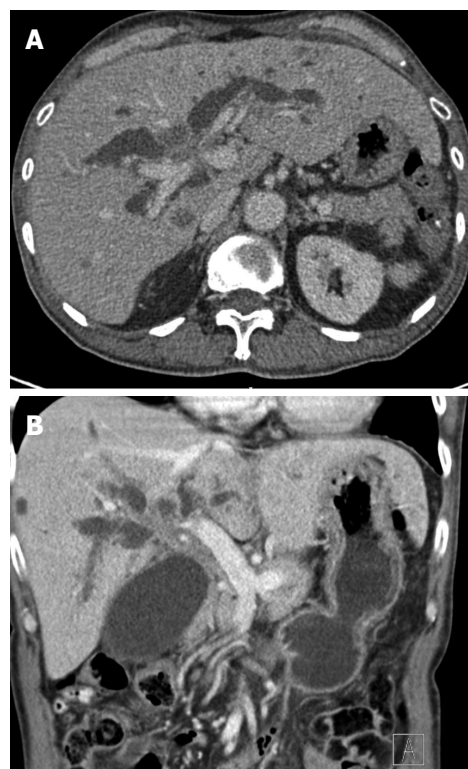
Computed tomography examination. A: Axial; B: Coronal computed tomography images showing an ill-defined mass in the hilar region causing bilateral intrahepatic duct dilation.
